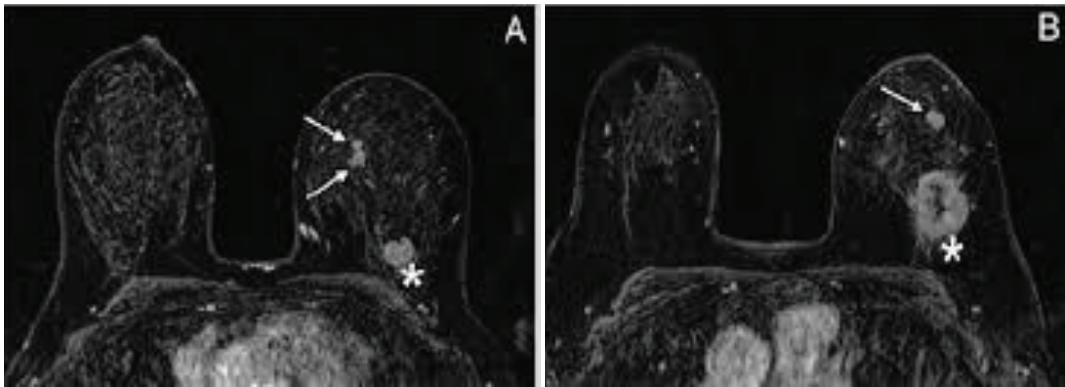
MRI images of breast cancer
